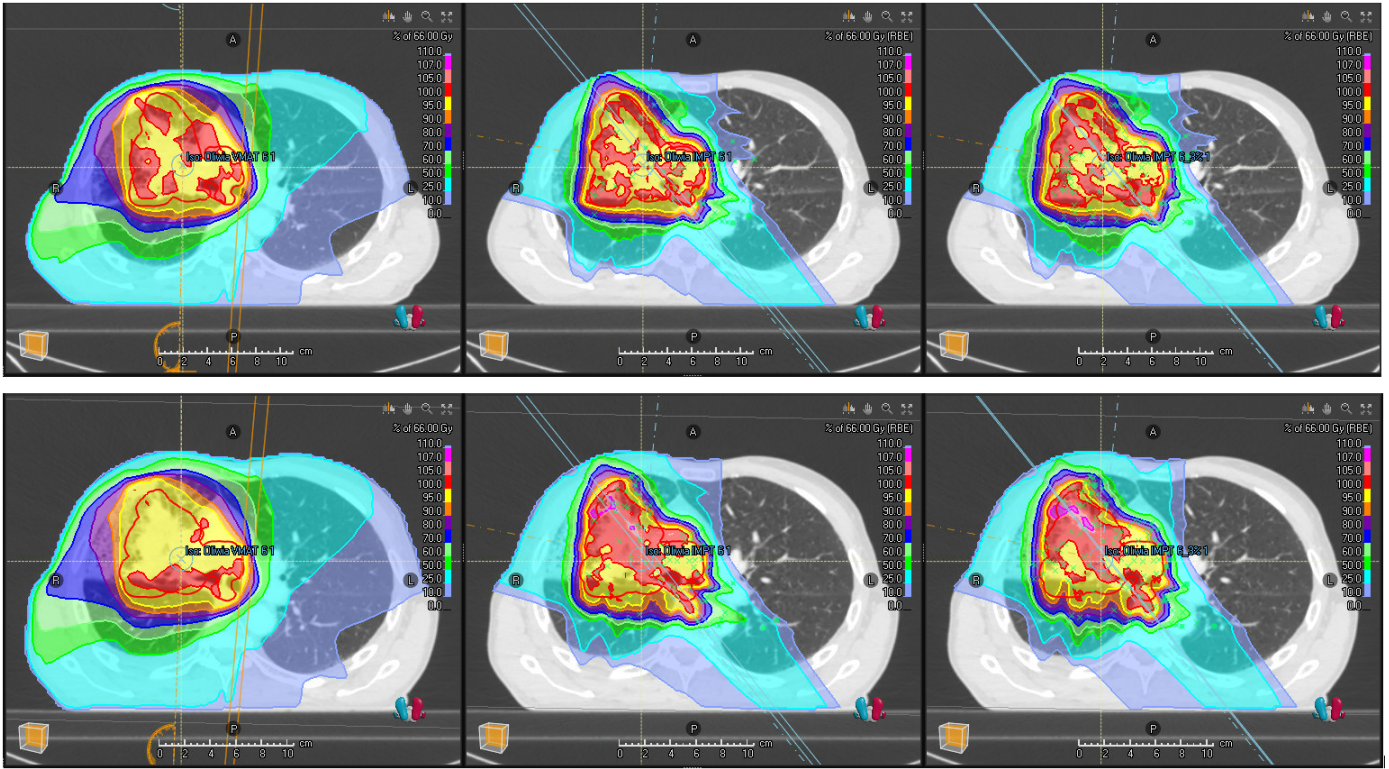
Dose distribution for patient 6 showing varying homogeneity. Images are from the three treatment plans, VMAT on the left side, IMPT_{4.5%} in the middle, and IMPT_{3%} on the right side. The CT 2 version of each is included below.
